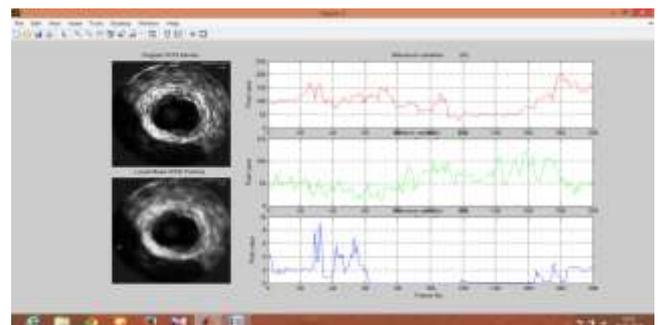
Local mean evolution of different pixels. On the left, the original intravascular ultrasound sequence (top image) and the one corresponding to local mean (bottom image). On the right, the graphics of the evolution of three pixels, a pixel at a salient feature (top), a pixel at lumen-tissue transition (middle), and a motionless pixel (bottom).
